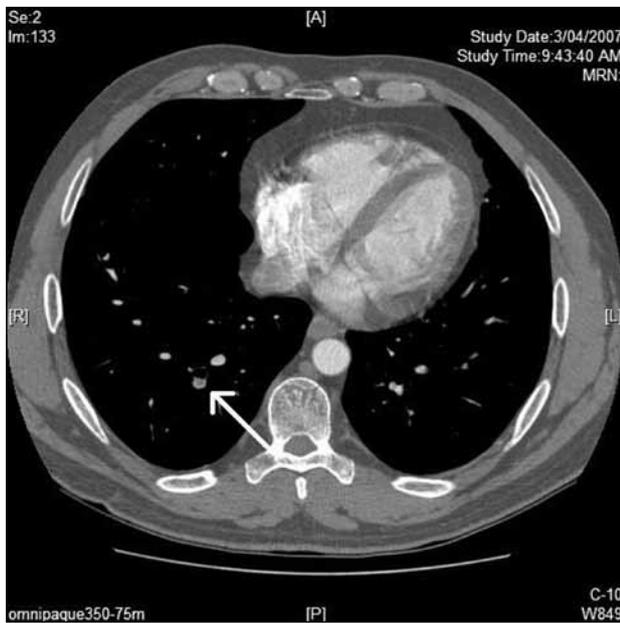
Computed tomography of the chest showing a partial resolution of the right lower lobe pulmonary artery aneurysm (arrow) after three months of corticosteroid and azathioprine treatment. A small thrombus is still visualised within the lumen of the artery.
